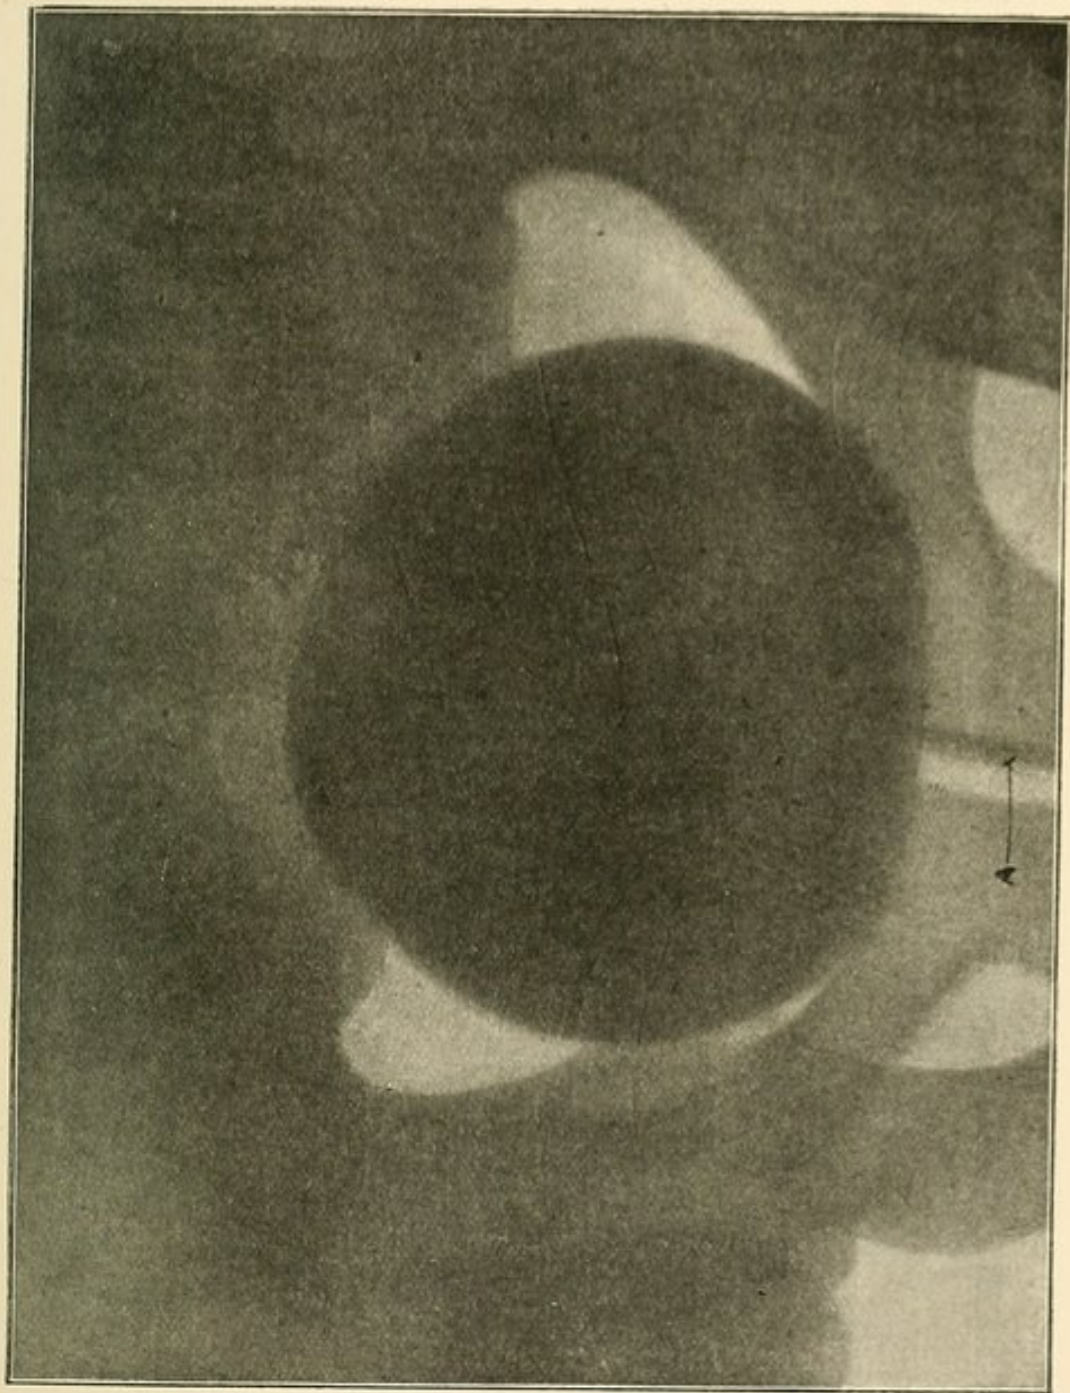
Radiograph of a fully-distended Bladder. A, Metal bougie lying in Urethra.
